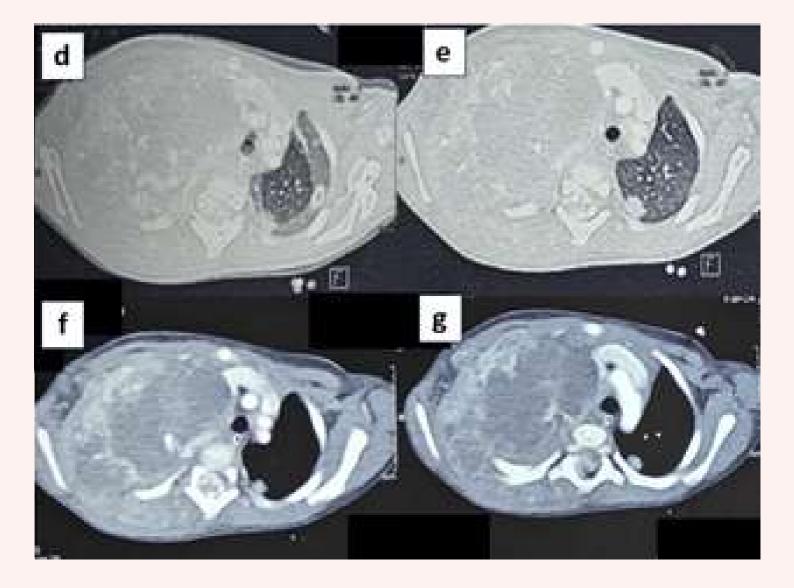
(a and b) A diffuse mass in the right supraclavicular, axillary, infraclavicular, and suprascapular region. (c) Chest radiograph showing homogenous opacity with calcification with destruction of first two ribs and pushed down third and fourth rib. (d-g) CECT chest showing a well-defined heterogeneous mass in the right hemithorax measuring 8 X 7.6 X 8.7 cm extending superiorly up to the root of the neck causing compression and inferiorly into posterior mediastinum and extending into the spinal canal from C7 to D2. Right first rib is completely encased by a lesion & not visualized. There is displacement of right subclavian vessels, brachiocephalic vessels and superior venacava. Near complete collapse of the right lung.
